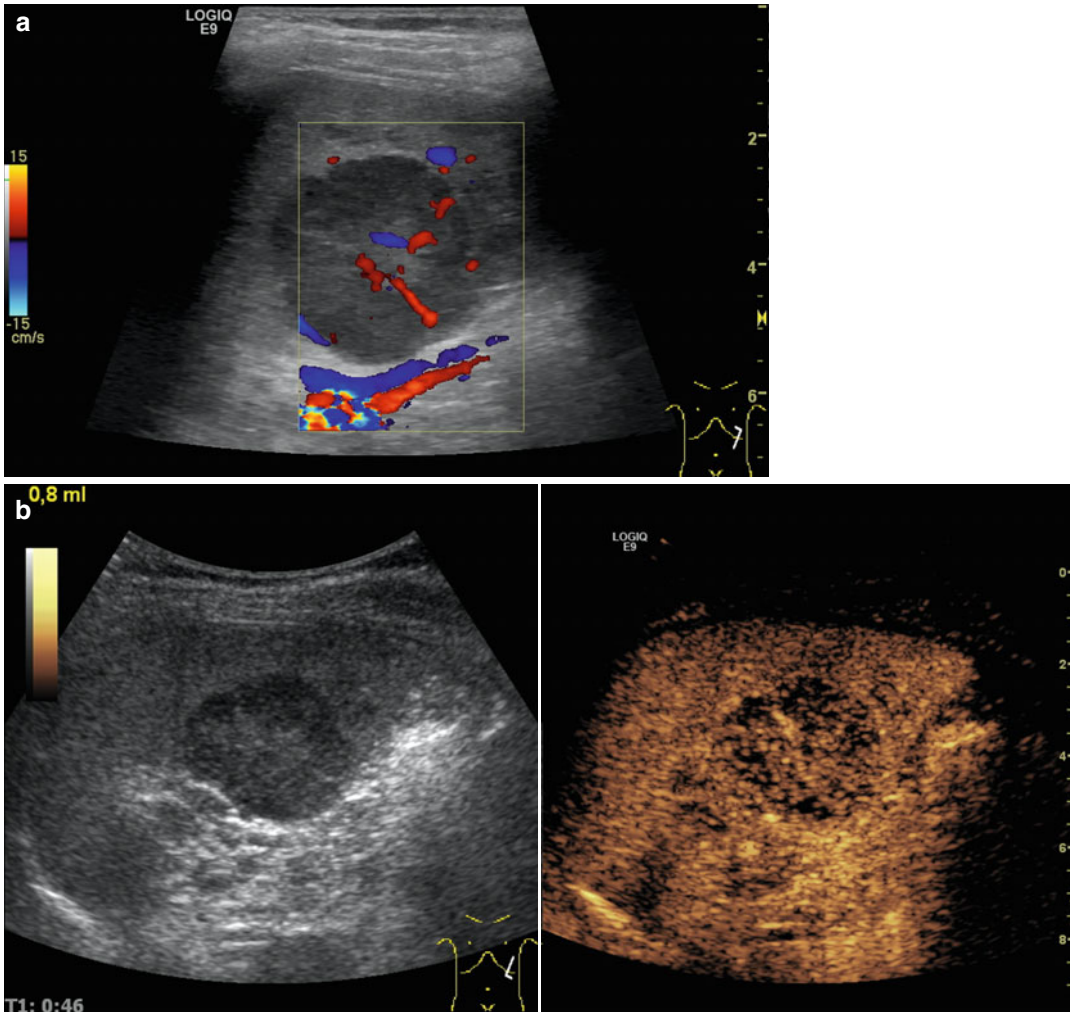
Hodgkin's lymphoma of the spleen in a 9-year-old boy with back pain. (a) A single large sized nodular lesion >3 cm and multiple small lesions with vessels inside the nodule seen in CDS. Longitudinal section. (b) Contrast-enhanced ultrasonography (CEUS)
